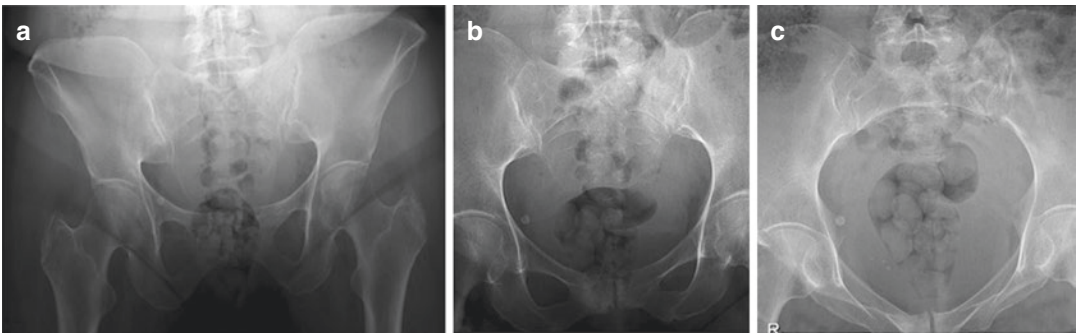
Plain radiographs including (a) AP pelvis and (b, c) pelvic views demonstrating sclerosis in the left sacral ala suggestive of SIF
